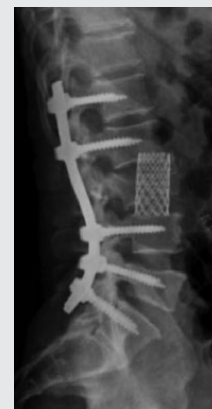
Standing post-operative radiograph following posterior-anterior approach.
